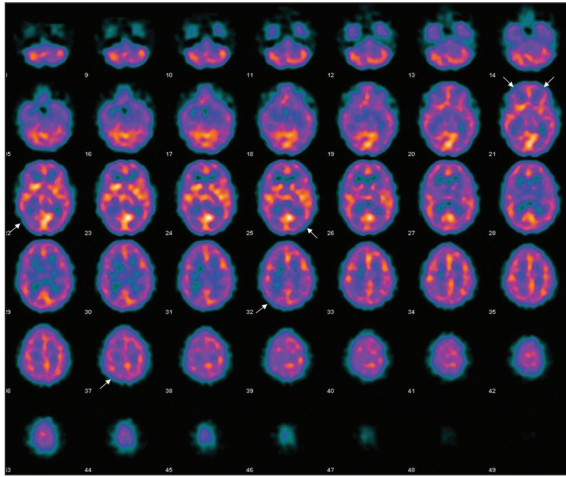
We show transaxial brain single-photon emission computed tomography images with irregular and patchy decreased cortical tracer uptake of both hemispheres (arrows)
